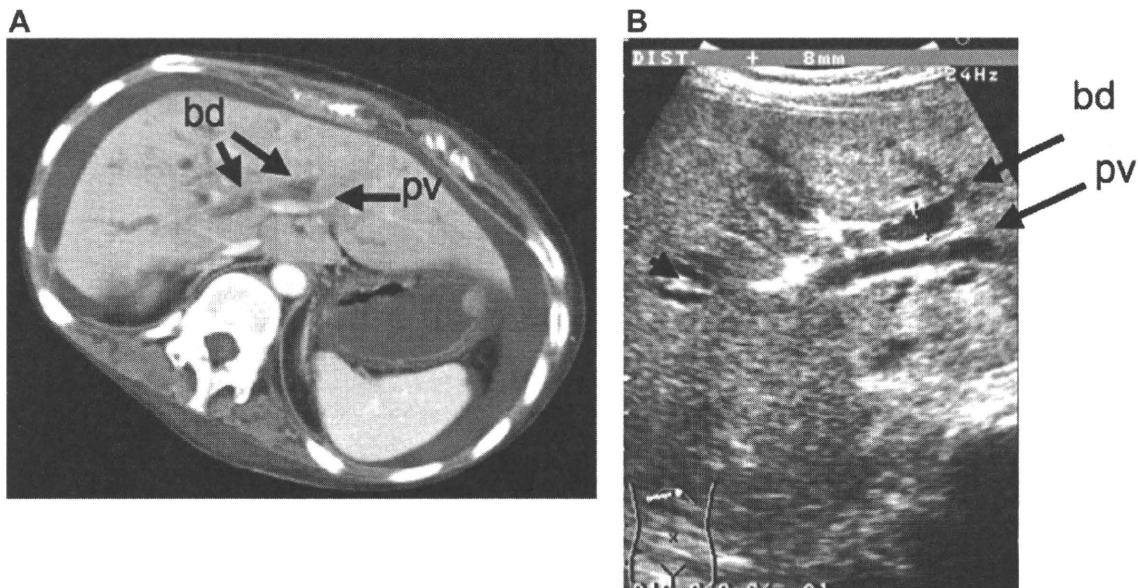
(A) Enhanced computed tomography of the abdomen showing dilatation of the intrahepatic bile duct (bd) and obstruction of portal vein (pv). (B) Ultrasonography of abdomen showing dilated intrahepatic bile duct (bd) and its accompanying hepatic portal vein (pv) with “parallel channel sign” of biliary obstruction.
